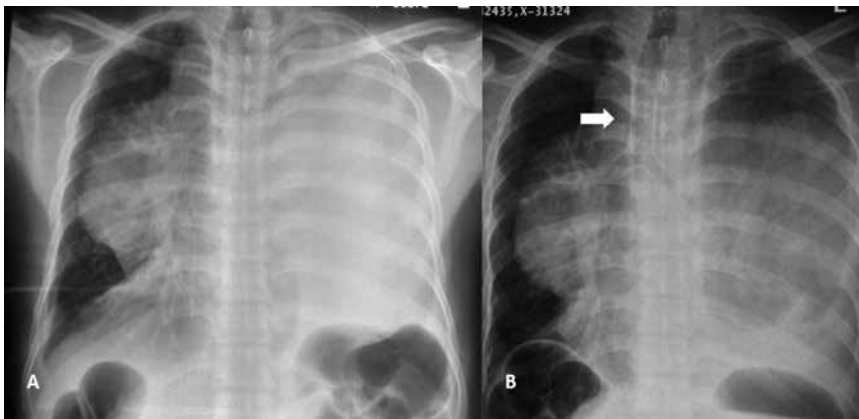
Chest radiograph of a 34-year old male with stridor due to extrinsic compression by bulky mediastinal and lung masses (A). The patient underwent emergency rigid bronchoscopy and palliative stenting (covered metallic Y stent denoted by arrow) (B). Biopsy of the bulky tumour revealed poorly differentiated sarcoma.
